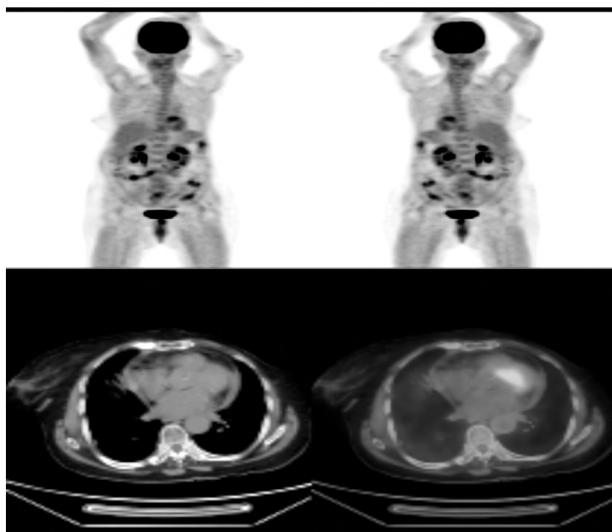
PET-CT revealed free surveyed body from any metastatic foci.
